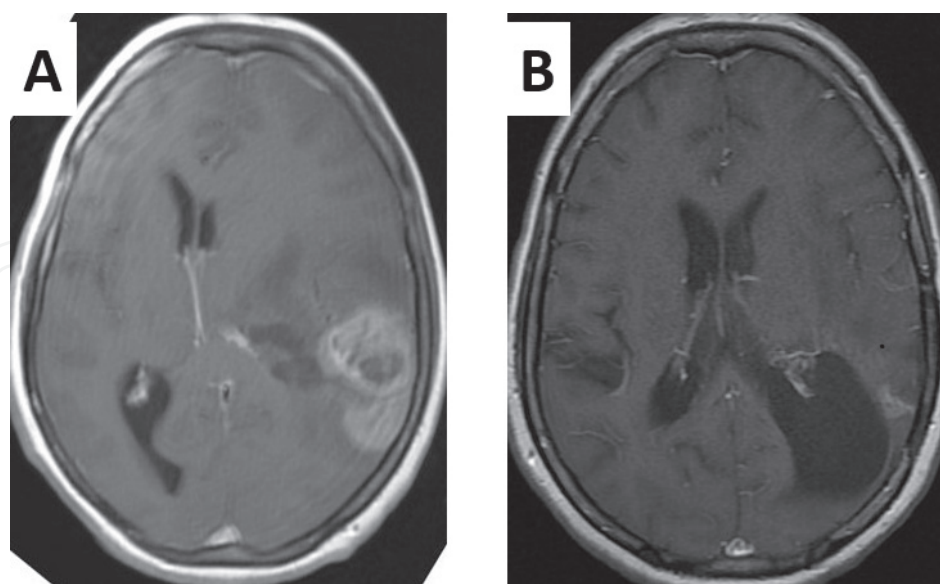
Contrast-enhanced axial T1 MRI scan of 54-year-old female patient with IDH-mutant glioblastoma. (A) Preoperative MRI and (B) 4 years after extensive surgical resection, followed with TMZ and radiotherapy treatment. Small part of recurrent tumor is visible 50 months after initial resection. Patient is still without any neurological deficit.
